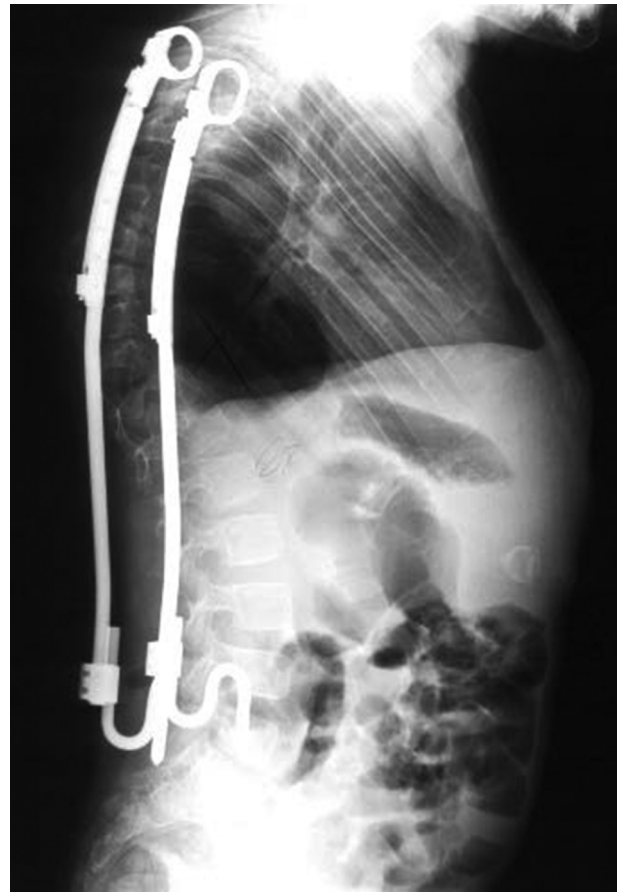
Lateral X-ray immediately after initial noncoated Vertical Expandable Prosthetic Titanium Rib placement.
